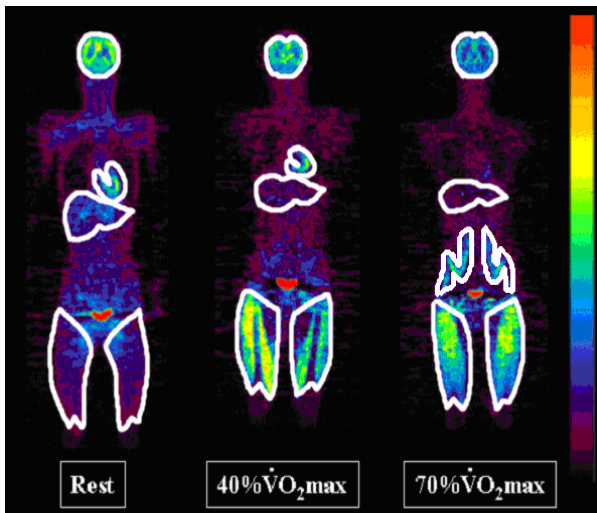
ROIs procedure and [ $^{18}\text{F}$ ]FDG uptake of individual organs at rest (left) and exercise loads; 40% and 70%  $\dot{\text{V}}\text{O}_{2\text{max}}$  (right).
